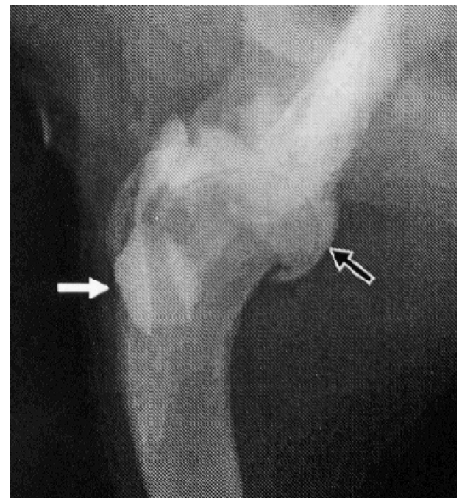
Medirolateral radiograph of the shoulder joint 5 minutes after the intraarticular injection of 30% Uropolin and 0.2 ml 0.1% adrenaline hydrochloride. The white arrow shows *vagina synovialis intertubercularis*, filled with contrast medium, and the hollow arrow outlines the joint cartilage.
